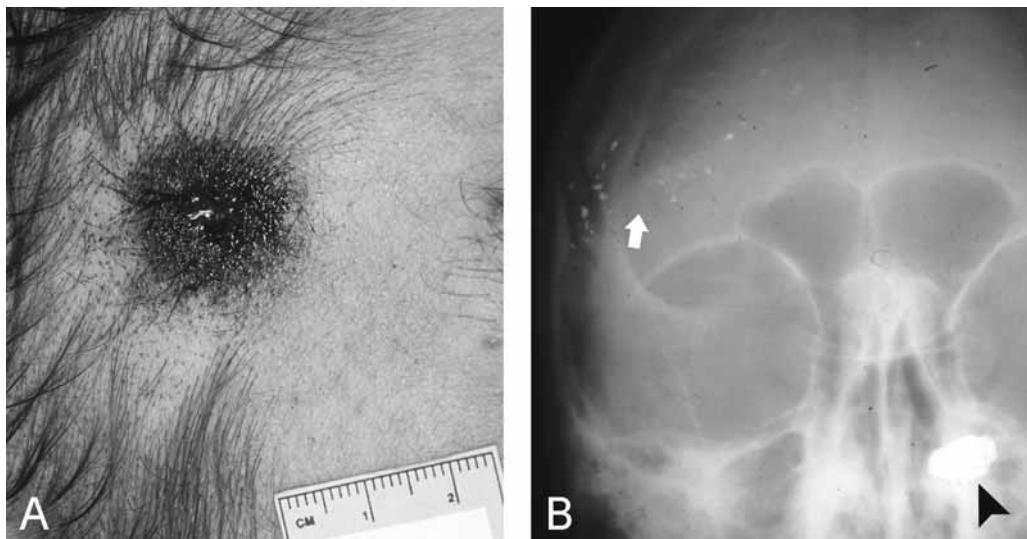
Intracranial bullet ricochet. (A) Near contact gunshot wound of right temple. (B) Radiograph of skull showing path of bullet fragments (arrow) from entry site along wound track. Large bullet fragment on left skull base (arrowhead).
